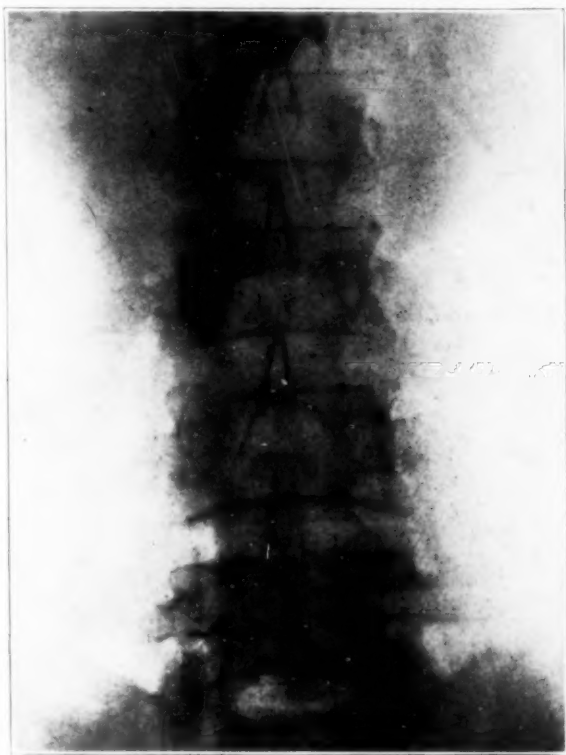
(case M. T.).—Roentgenographic appearance of iodized oil arrested at the second lumbar level. Compare with figure 13.
